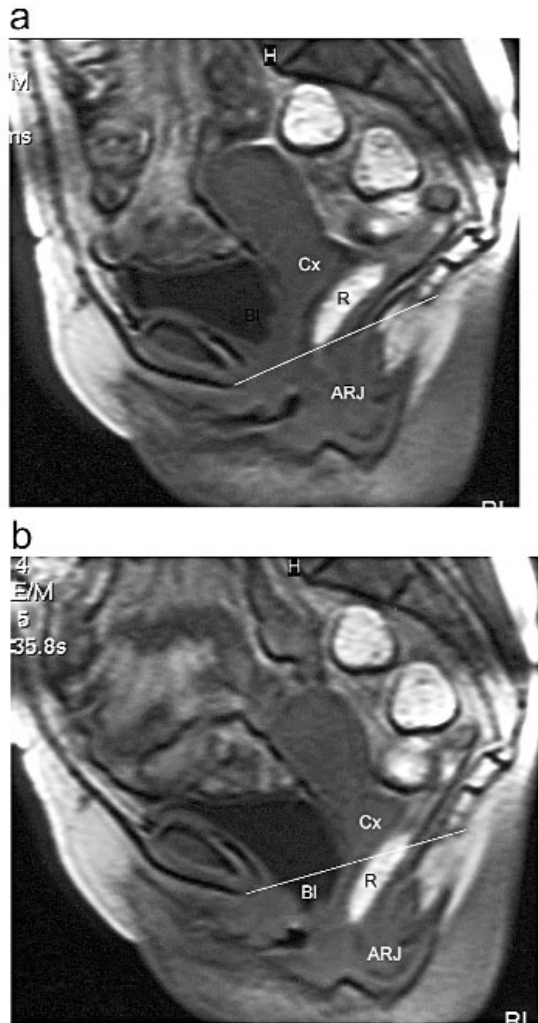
Sagittal views from a dynamic MRI examination. The dotted line indicates the position of the pubococcygeal line. At rest (a) there is some descent as the anorectal junction (ARJ) is more than 1 cm below this. During pelvic stress (b) there is marked pelvic floor descent, with descent of the cervix (Cx) and bladder base (BI).
